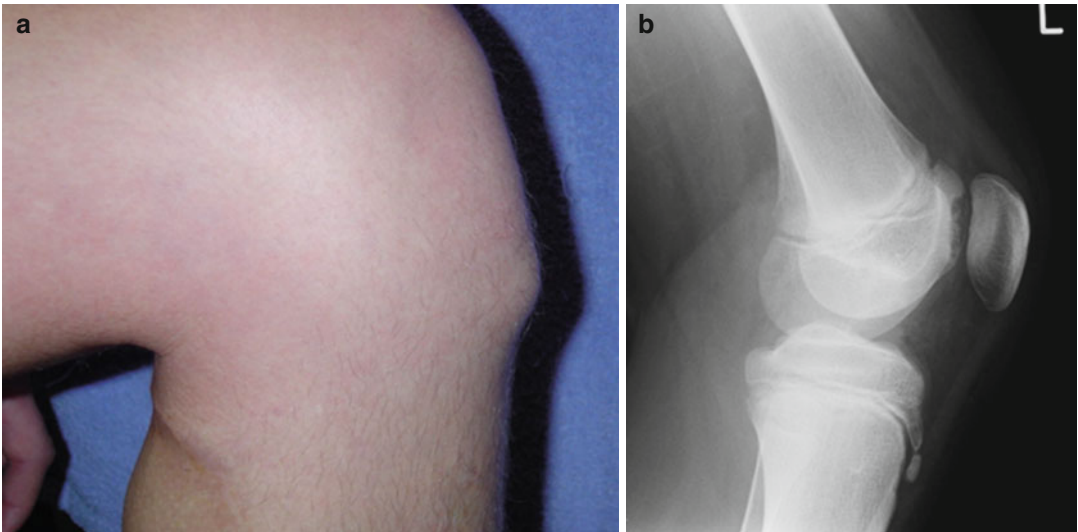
Traction apophysitis of the tibial tuberosity, “Osgood-Schlatter disease.” The tibial tuberosity is prominent (a) and there is a small ossicle on the lateral radiograph (b)
